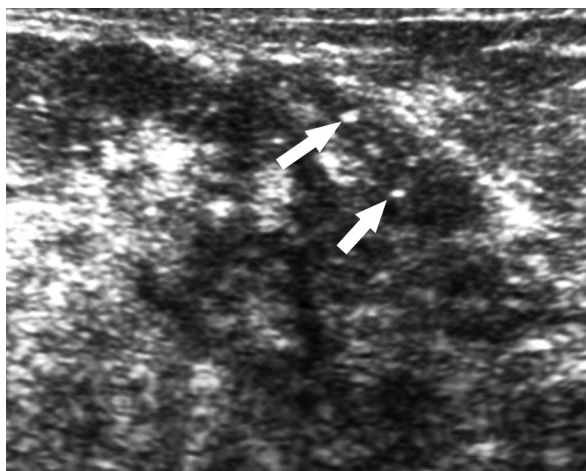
A 77-year-old woman with remote history of invasive and *in situ* ductal carcinoma. Cropped grayscale ultrasound image depicts dilated ducts extending from the nipple with intraductal calcifications (arrows). Ultrasound-guided vacuum-assisted core biopsy of the calcifications yielded high-grade ductal carcinoma *in situ* with comedonecrosis.
